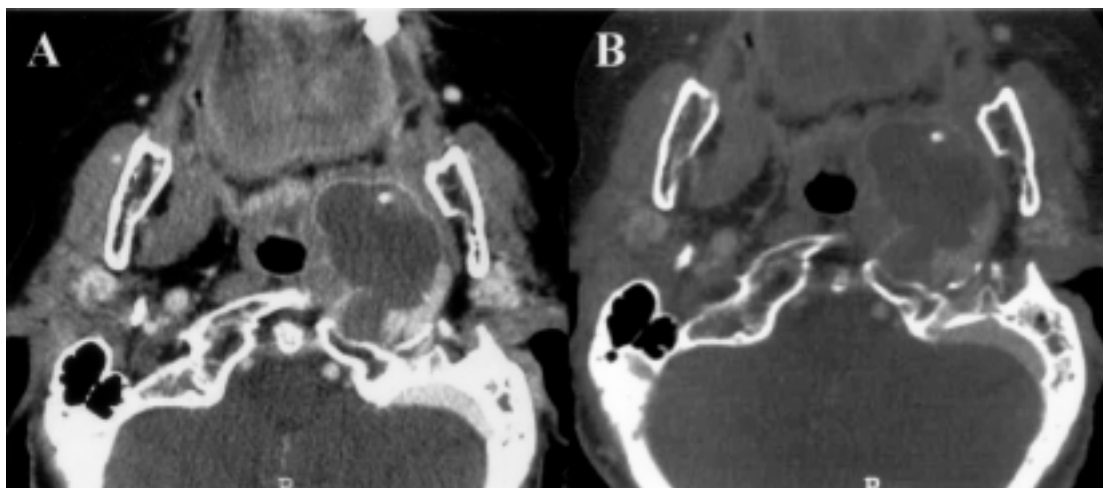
CT scan revealing a left parapharyngeal kystic mass (A). Bone window (B) demonstrates erosion of the skull base
